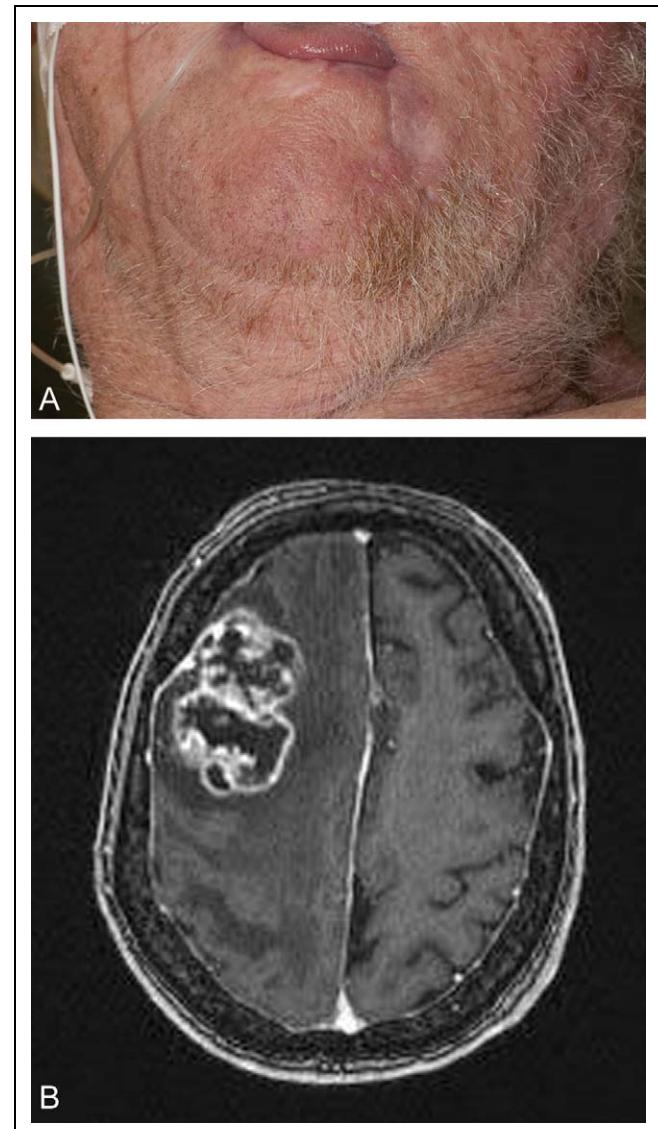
A, Anterior view of the patient's face. B, T1-weighted magnetic resonance image (MRI) with gadolinium revealed a large lobulated enhancing mass in right frontal lobe with vasogenic edema extending into the parietal lobe causing midline shift.
